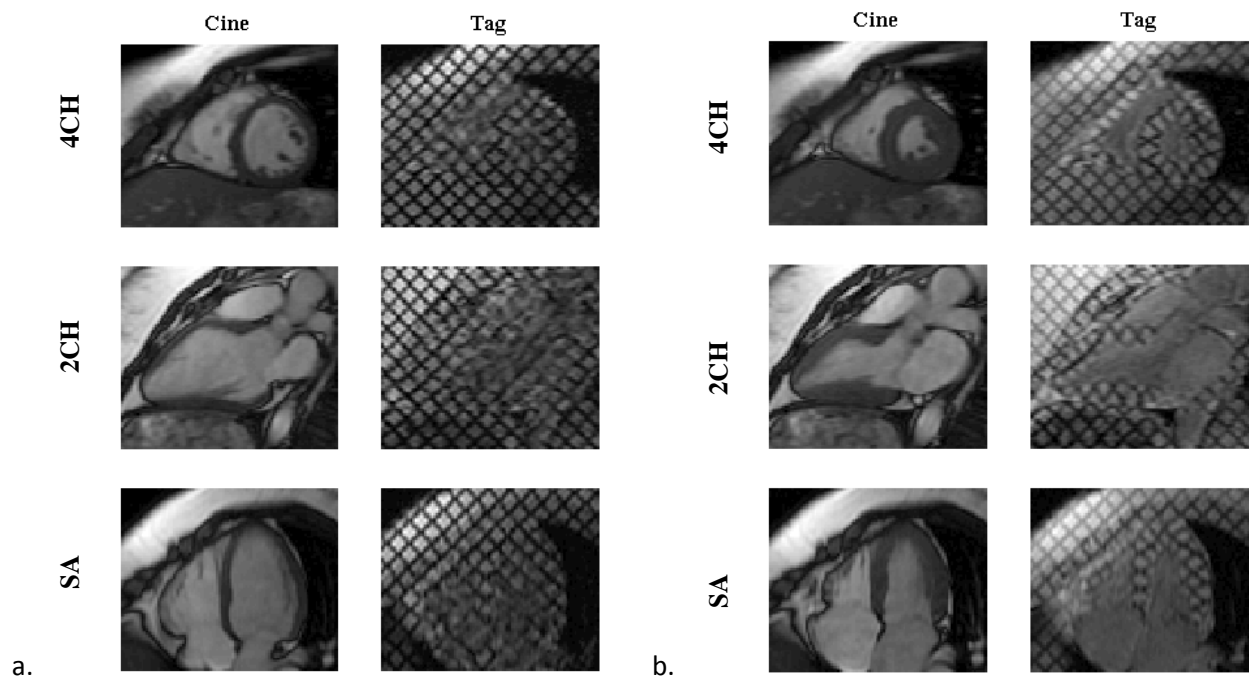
Cine and tagged MR images at a. ED and b. ES of a normal volunteer
